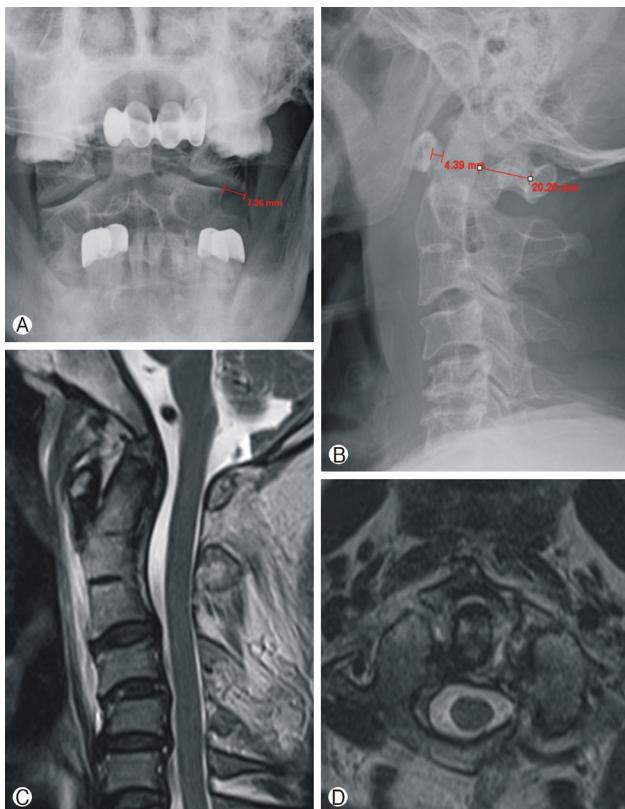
(A) Preoperative open mouth view, showing a 7.26 mm displacement of the left C1 lateral mass to the C2 lateral mass. (B) Preoperative lateral X-ray showing a 4.39 mm atlanto-dens interval and a C1 canal diameter of 20.20 mm. (C) Preoperative T2-weighted midline magnetic resonance sagittal image showing an absence of cord compression. (D) Preoperative T2-weighted magnetic resonance axial image at C1-C2 level revealing a Jefferson fracture, injury to the transverse ligament, and dural compression of the left side fractured lamina.
